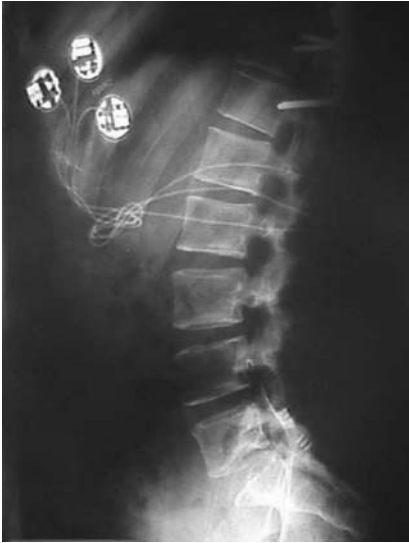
Postoperative X-rays of an implanted patient. Note the osteosynthesis of the spine for T10 fracture responsible of paraplegia
